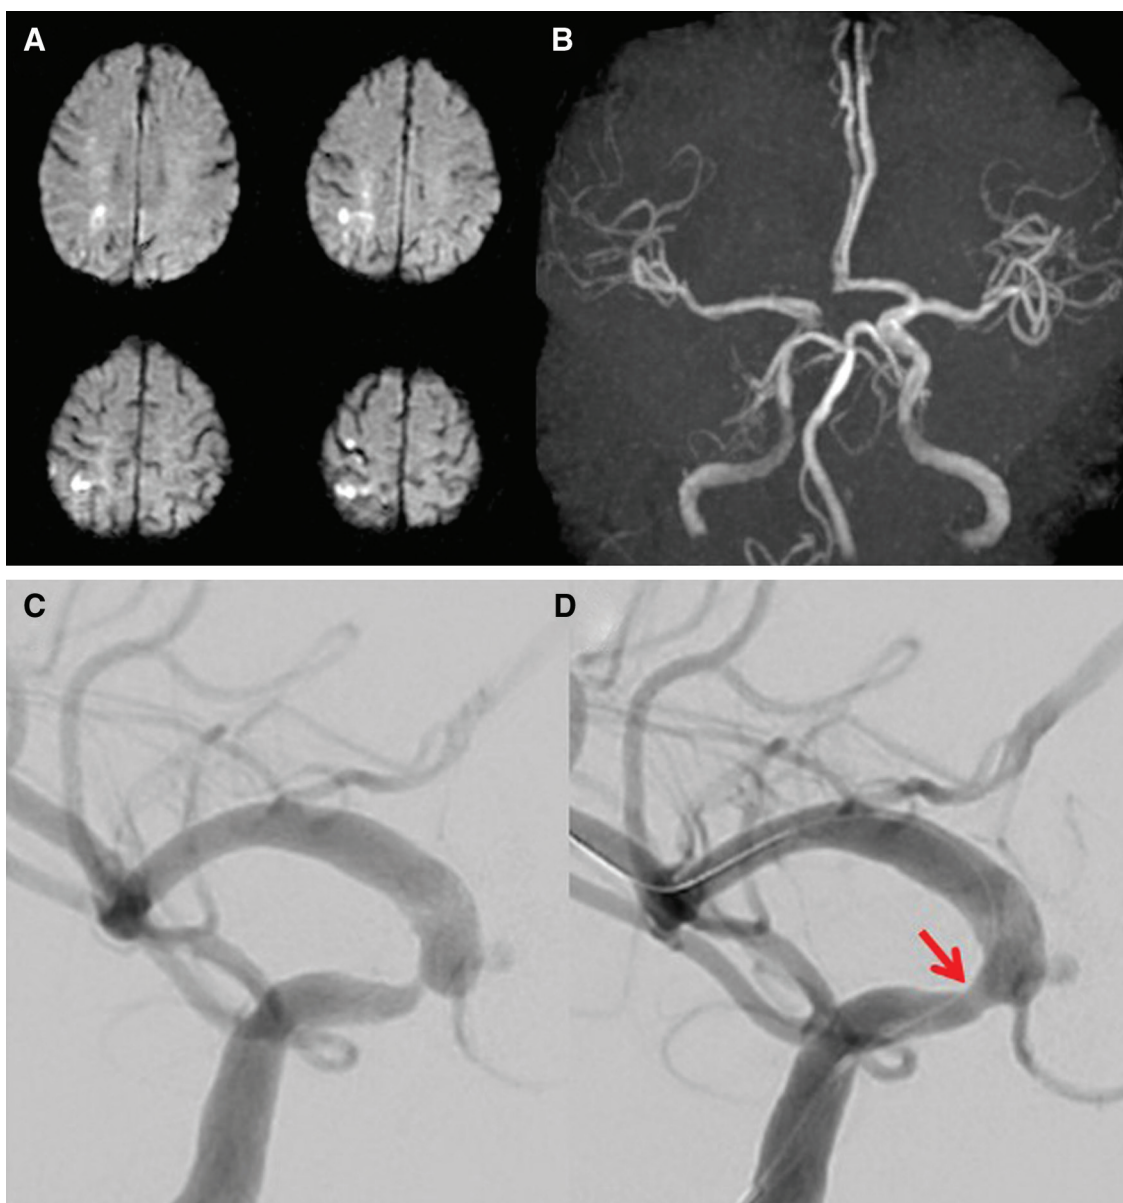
Initial MRI and intraoperative findings of the balloon angioplasty. (A) Initial diffusion-weighted imaging showing infarction in the right hemisphere. (B) Initial magnetic resonance angiography showing low intensity of the right ICA angiogram, before (C), and after (D) the balloon angioplasty procedure in the first surgery, showing improvement in the stenosis (arrow). ICA: internal carotid artery; MRI: magnetic resonance imaging.
